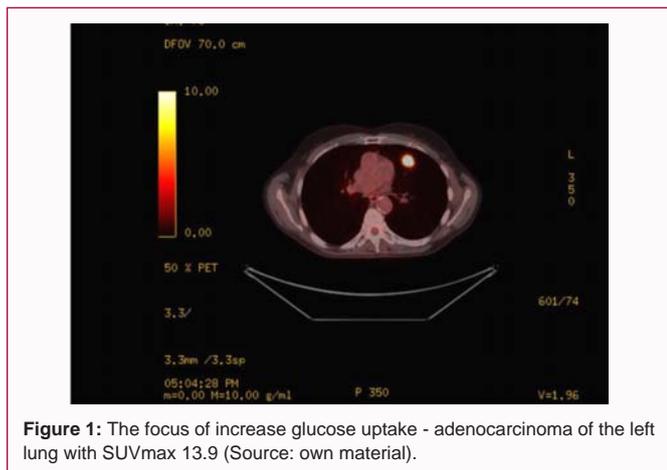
The focus of increase glucose uptake - adenocarcinoma of the left lung with SUVmax 13.9 (Source: own material).
